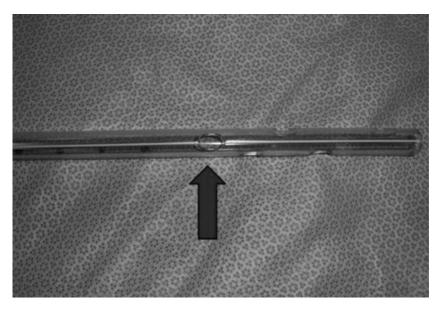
Make certain that the most proximal hole is inside the thoracic cavity. This hole crosses the radiopaque line on the tube (shown) and aids in detecting its proper placement on chest radiograph. From *Tube Thoracostomy Insertion*, by S. L. Melendez and M. A. Silverberg, 2012. Retrieved from https://reference.medscape.com/features/slideshow/tubethoracostomy. Copyright 2012 by Medscape Drugs & Diseases, WebMD LLC. Reproduced with permission.
